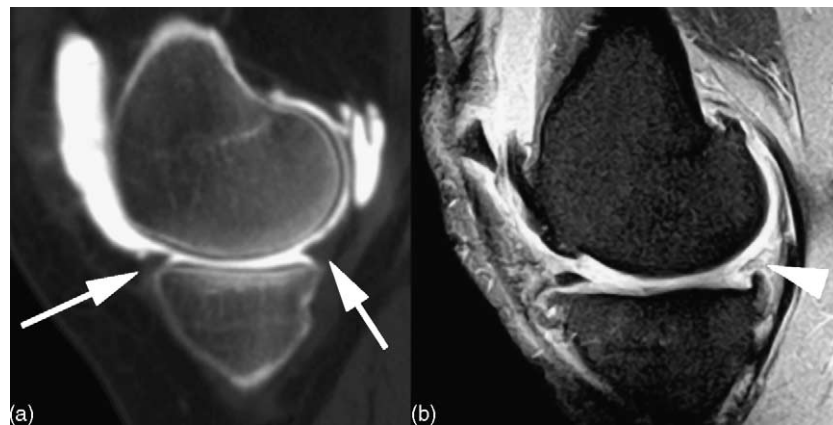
(a) Sagittal image from a CTA following a circumferential partial meniscectomy. Both anterior and posterior horns (arrows) are reduced in size but the outer third of the meniscus has been preserved throughout. (b) Sagittal fat-saturated proton density demonstrates an absent posterior horn (arrowhead) of the medial meniscus following a segmental resection. Subsequent osteoarthritis is indicated by large marginal osteophytes.
